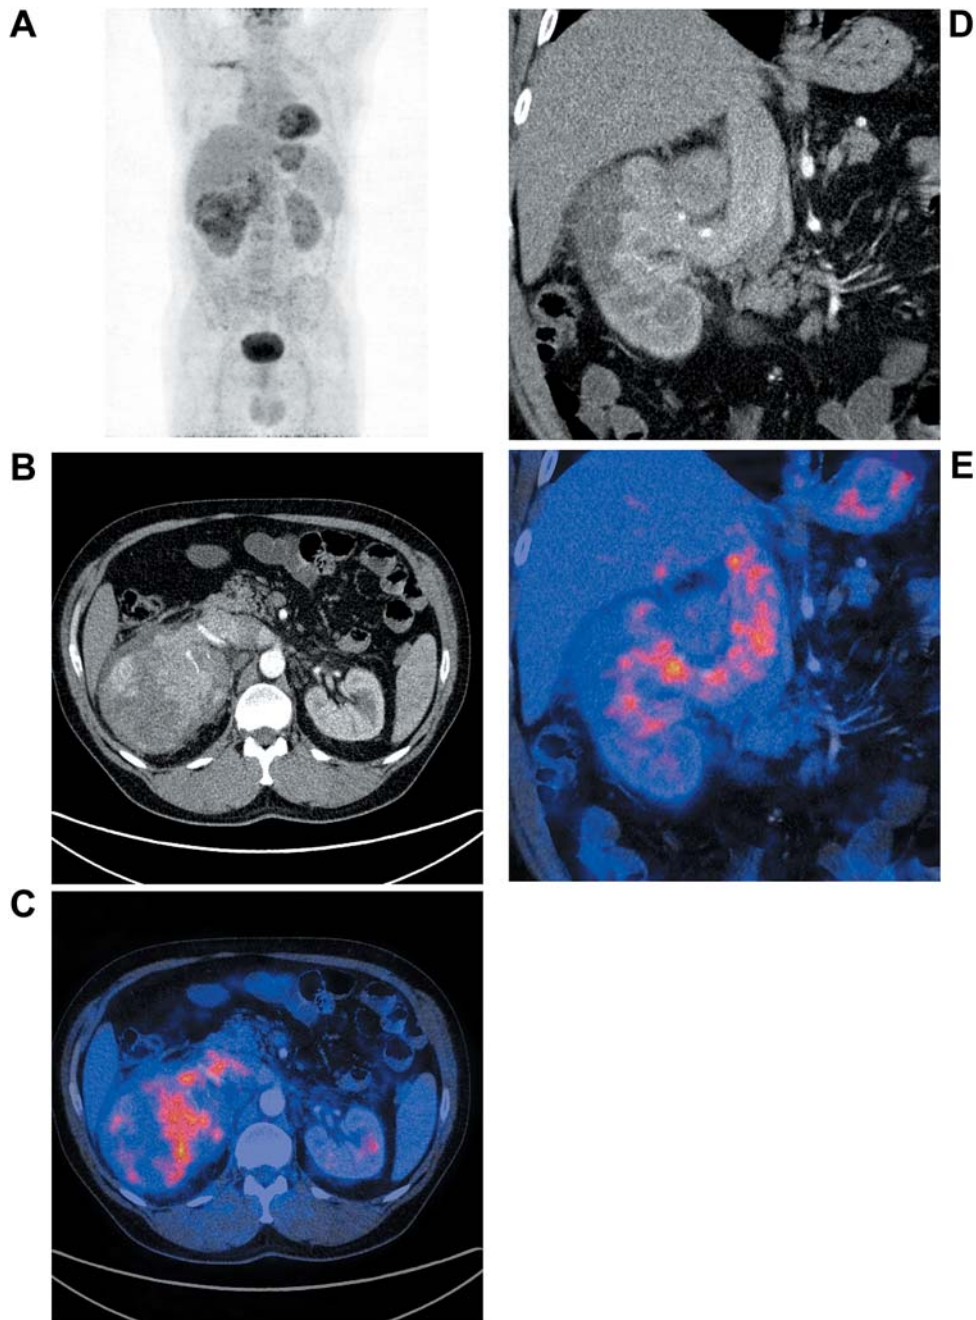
patient surviving more than 48 months after nephrectomy and removal of the tumorous thrombus from the inferior vena cava, conventional renal cell carcinoma well differentiated with relative low level accumulation of FDG. A – whole body MIP PET; B, D – CT images, C, E – PET/CT fusions – levels of displayed  $\text{SUV}_{\text{max}}$  0-10.
